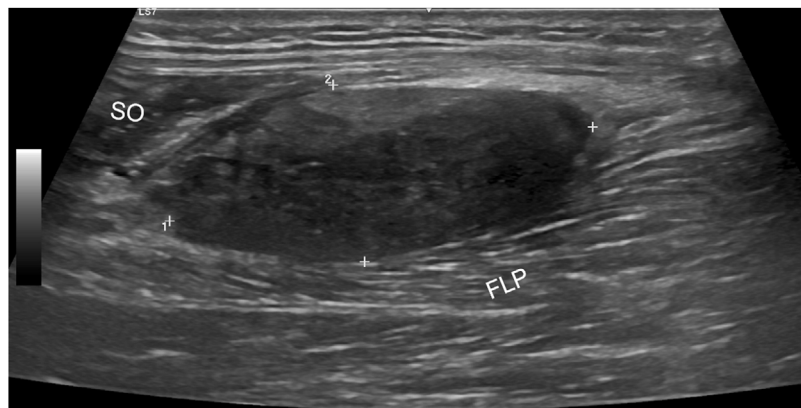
Ultrasound image of the posterior margin of the calf, with a solid nodule with well-defined margins (marked between calipers), of heterogeneous structure, mostly hypoechoic, with no cystic areas or peritumoral edema, localized between the muscle belly of the flexor digitorum longus (FLP) and the soleus (SO).
